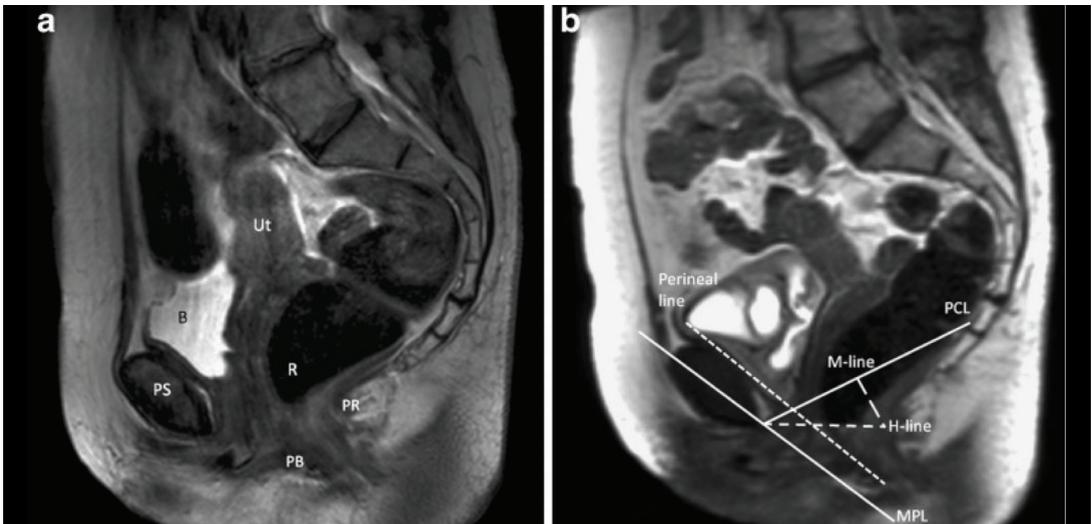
A static T2-weighted turbo spin echo (TSE) at rest for anatomical reference in the midsagittal plane through the pelvis of a 66-year old woman with pelvic organ prolapse (POP) symptoms. The uterus (Ut), bladder (B), pubic symphysis (PS), rectum (R), and puborectal (PR) are shown. Adapted (pending author permission) from Lakeman et al (29).
